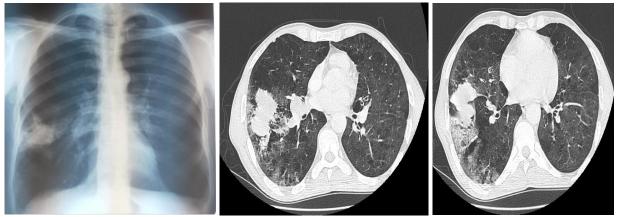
An X-ray and CT scan of the chest show a pulmonary tissue process
